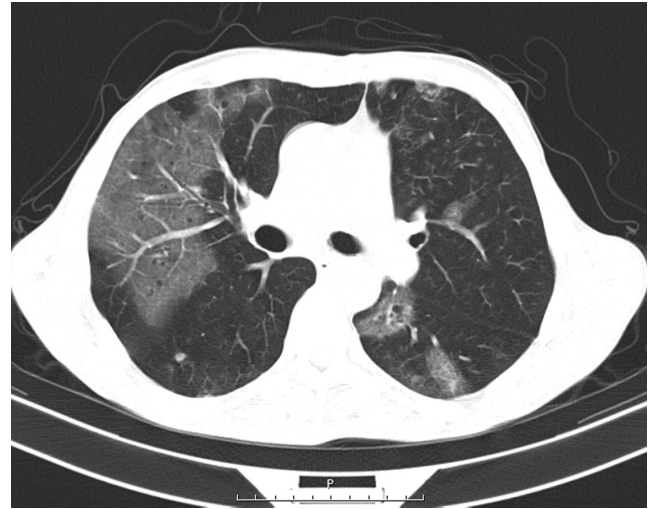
Lung CT scan showed bilateral multifocal ground glass opacities
